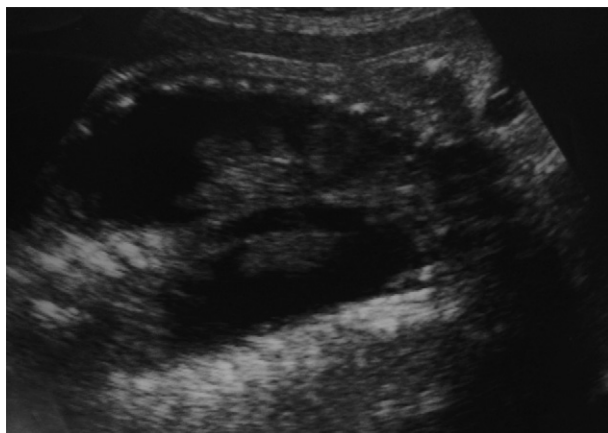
Prenatal ultrasound demonstrating the presence of bilateral large amount of pleural effusion.
